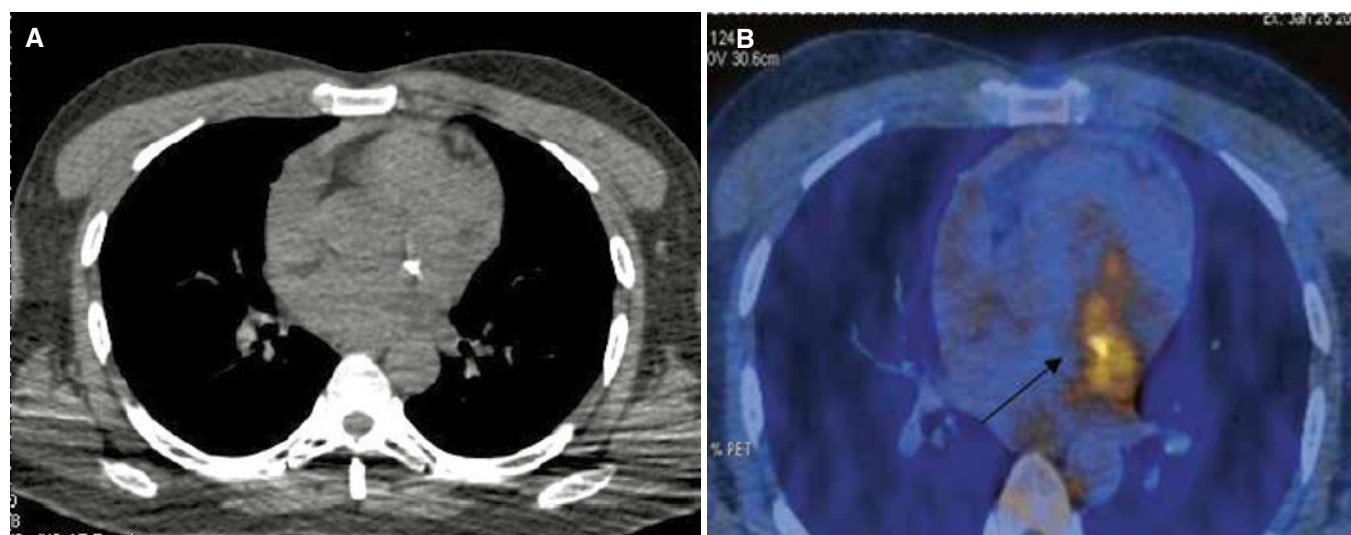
FDG PET scan axial section showing enhanced metabolic activity in the left AV groove along the stent
